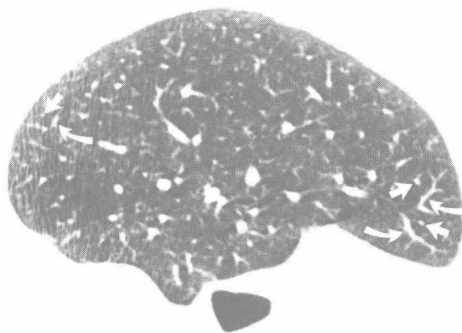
Normal 10-mm collimation CT scan through the upper lobes. The vessels can be seen as branching structures.
